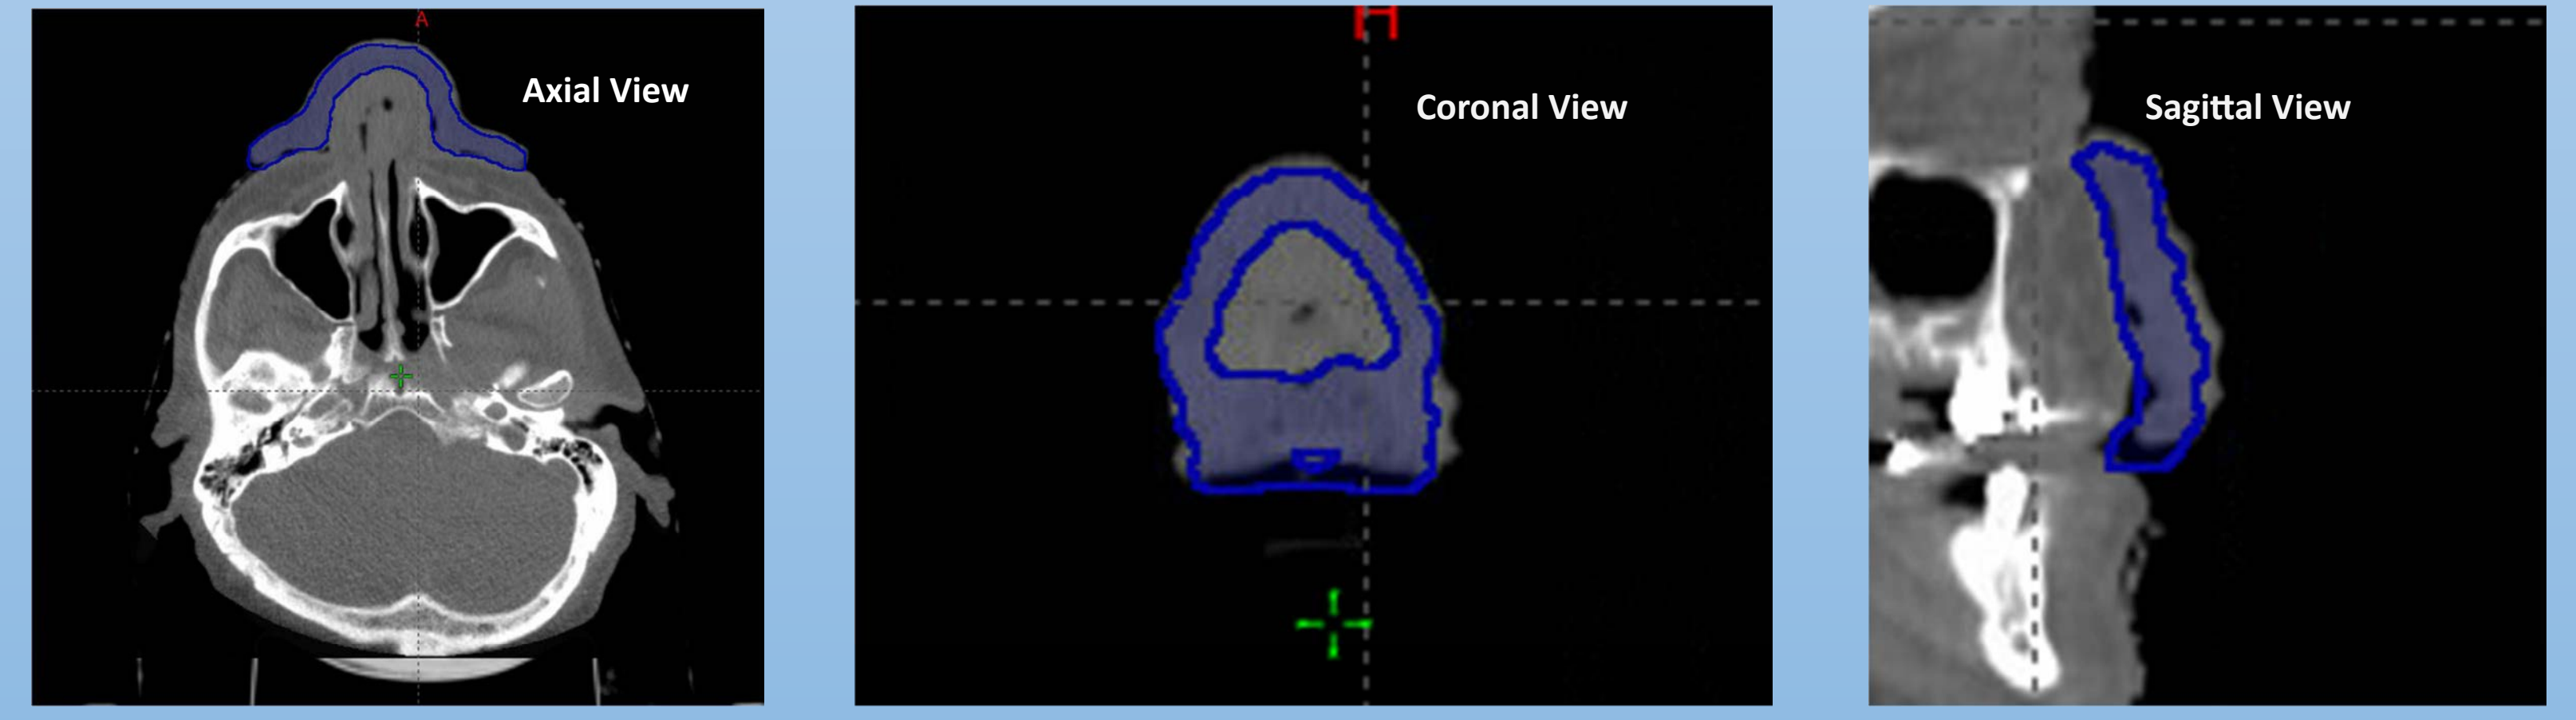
In Eclipse treatment planning system, 1st day CBCT overlaid on planning CT with TPS bolus outline visible. CBCT captured bolus matches well with TPS generated custom bolus outline on axial, coronal, and sagittal planes.
